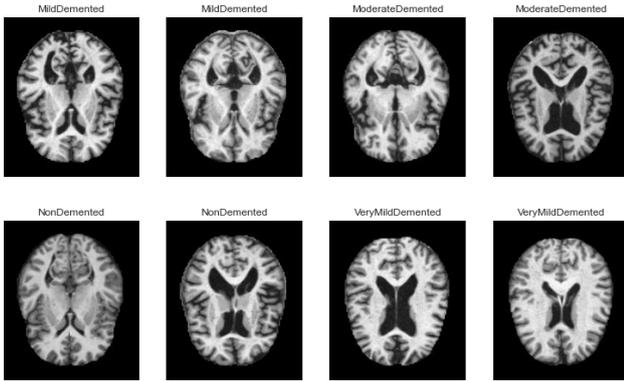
The sample MRI images from the OASIS dataset.
